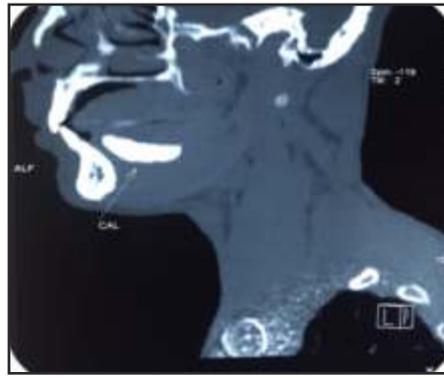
Sagittal CT scan showing calculus in the right submandibular gland duct.
